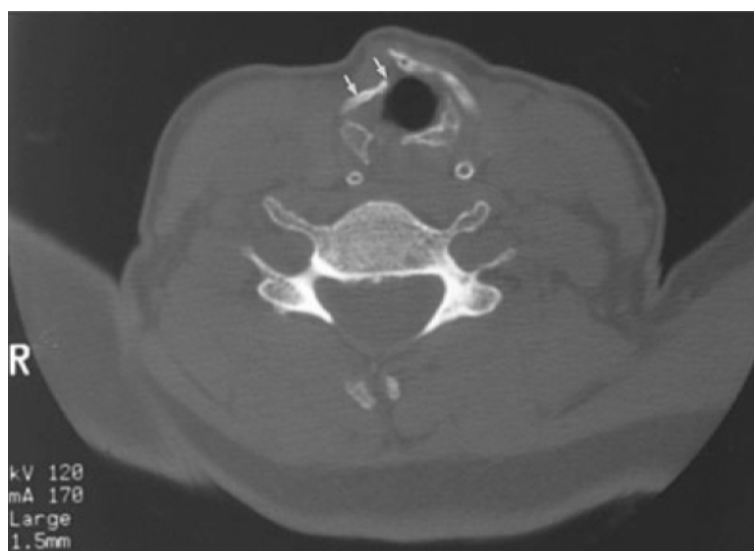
Computed tomography scan, axial view, demonstrating fractures involving the thyroid and cricoid cartilage (arrows).
